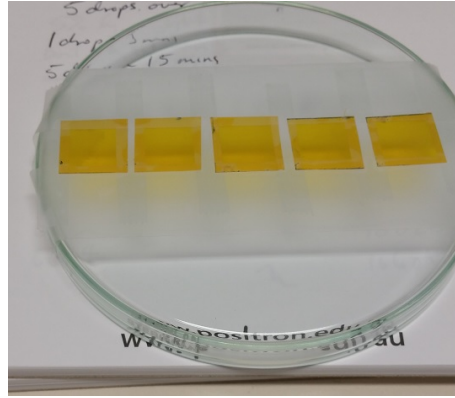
Uncoated mylar samples positioned for FDG evaporation trialling.
